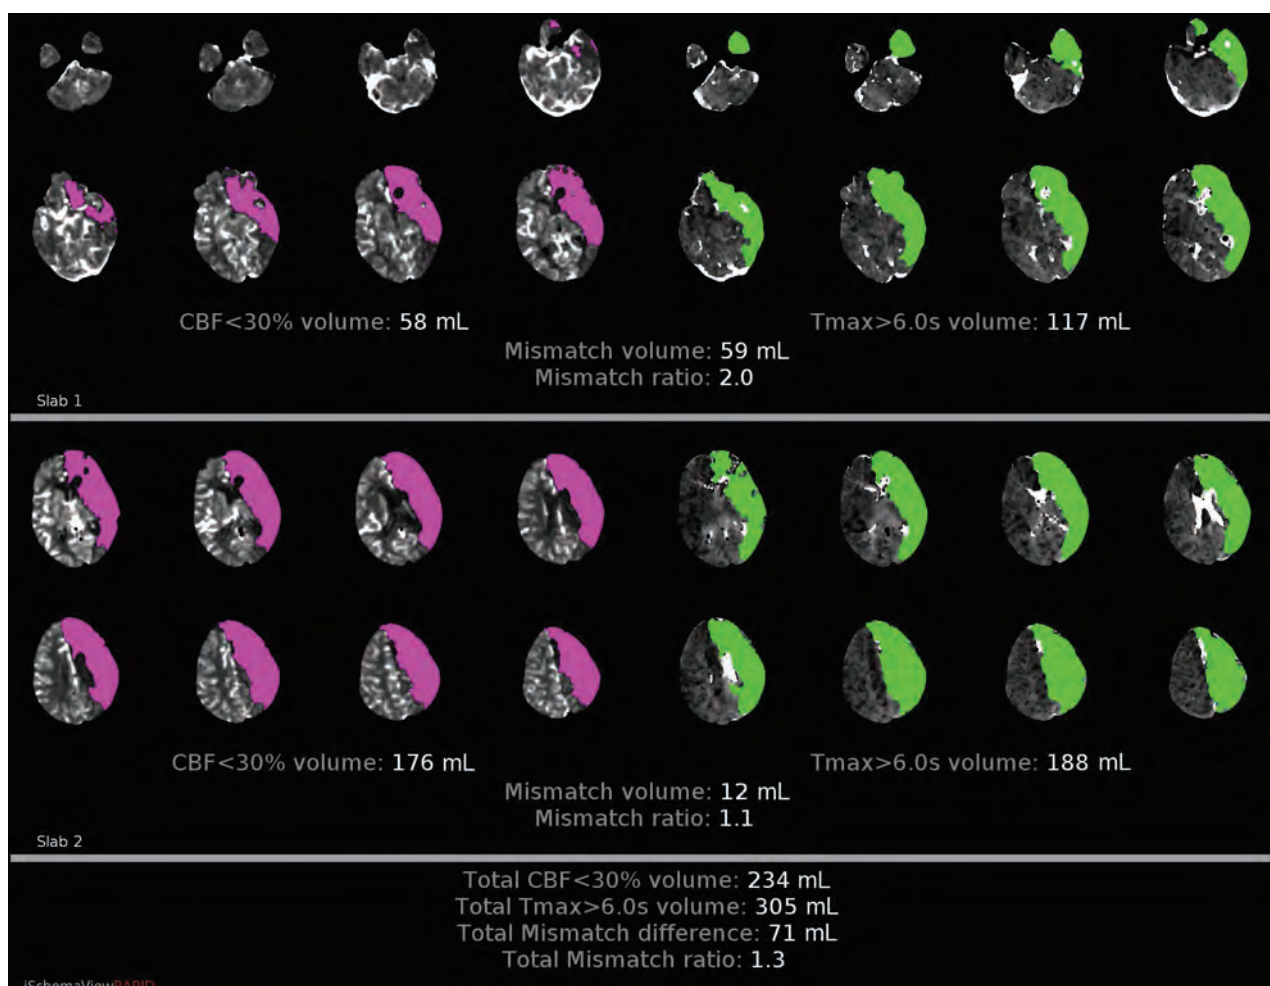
A 67-year-old man who presented directly to our institution (no recent IV contrast) with a left MCA syndrome and last known well approximately 8 hours before imaging. A and B, NCCT demonstrates hypoattenuation involving a large volume of the left MCA and anterior cerebral artery territories. C, CTA demonstrates a internal carotid terminus occlusion with involvement of the carotid terminus and A1 and M1 segments.
